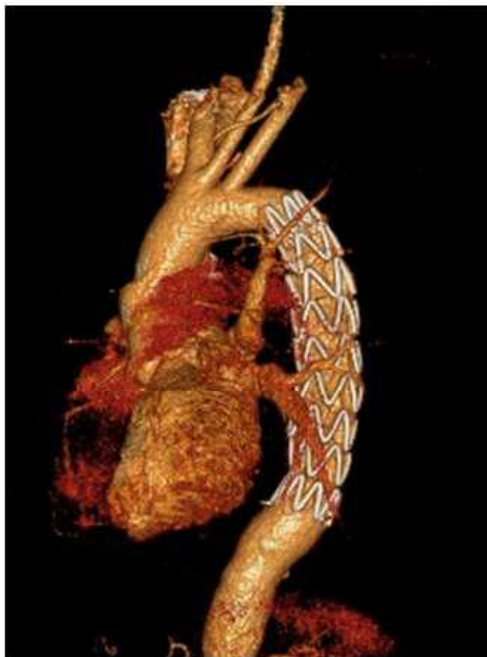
CT Aortogram of Thoracic Endovascular Stent for Descending Aortic Dissection
